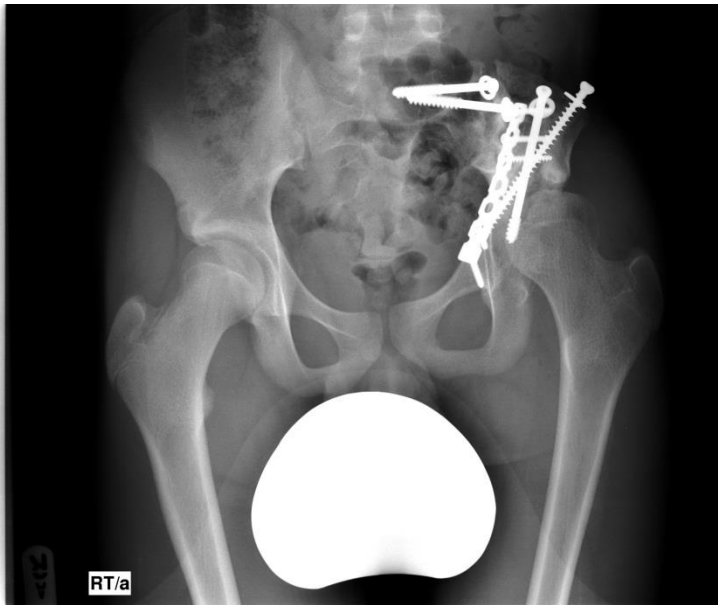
AP radiograph of the pelvis showing a type I resection, extracorporeal irradiation and re-implantation
